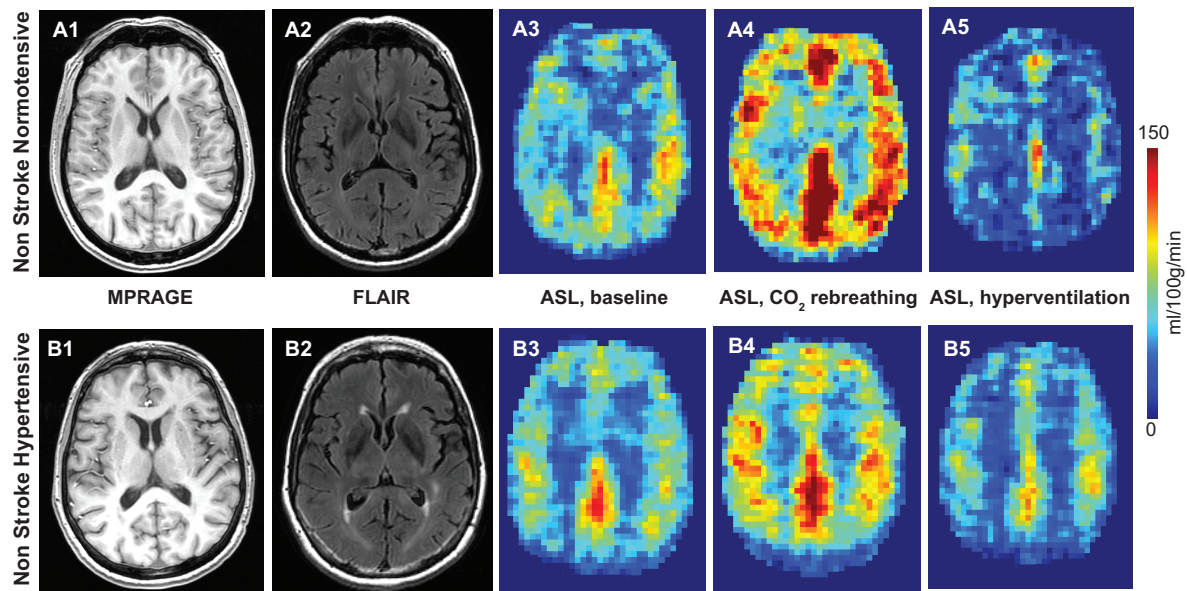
Anatomic and perfusion images for nonstroke normotensive subject (A1 to A5) and nonstroke hypertensive subject (B1 to B5). A1 and B1, Magnetization prepared rapid gradient echo (MPRAGE) images used for brain volume analysis. A2 and B2, Fluid-attenuated inversion recovery (FLAIR) images for WMH analysis. A3 and B3, Baseline cerebral blood flow. A4 and B4, CBF during CO₂ rebreathing. A5 and B5, CBF during hyperventilation. The perfusion scale is 0 to 150 mL/100 g per minute on all CBF maps. Nonstroke normotensive subject has similar baseline CBF, higher CBF during hypercapnia, and lower CBF during hyperventilation as compared with nonstroke hypertensive subject.
